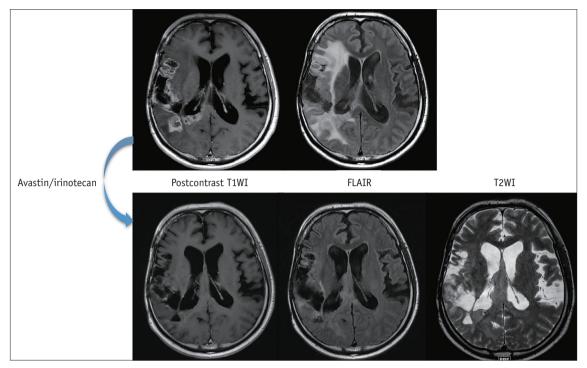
Recurrent glioblastoma in a 37-year-old male with heterogeneous enhancement along the resection margin on postcontrast T1WI and marked perilesional edema (upper row). After 10 cycles of Avastin and Irinotecan, contrast enhancement and edema improved significantly. However, FLAIR and T2WI demonstrate nonenhancing nodular lesions along the septum pellucidum, which suggests pseudoresponse. FLAIR = fluid-attenuated inversion-recovery, T1WI = T1-weighted image, T2WI = T2-weighted image
